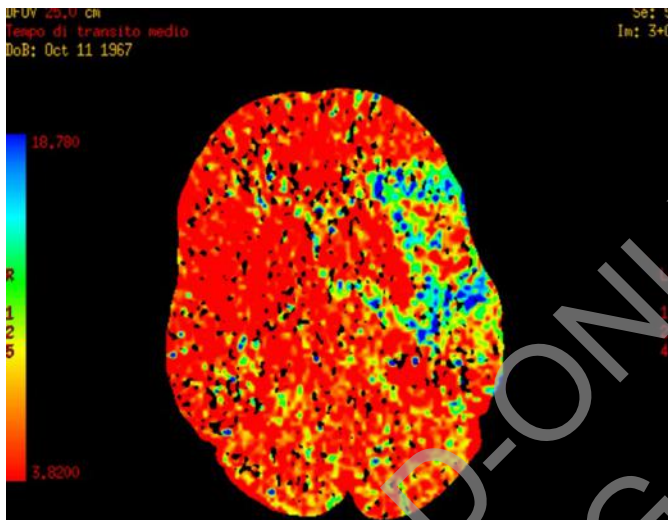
Cerebral artery blood flow reduction. The perfusion brain CT scan showed blood flow reduction in the territory of the middle left cerebral artery.
